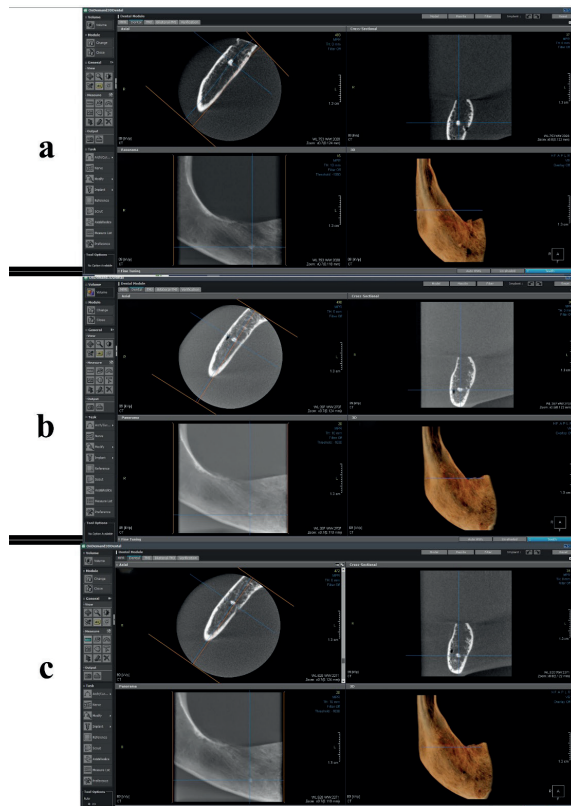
CBCT images of roots of different sizes. a) Presence of 1 mm root (horizontal); b) Presence of 2 mm root (horizontal); c) Presence of 3 mm root (horizontal)
